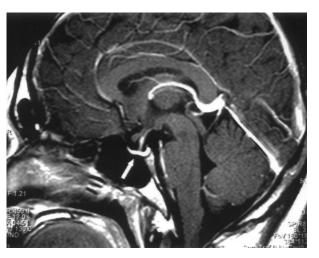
T1-weighted, sagittal, magnetic resonance imaging scan showing an extremely thinned anterior lobe of the hypophyseal gland.
